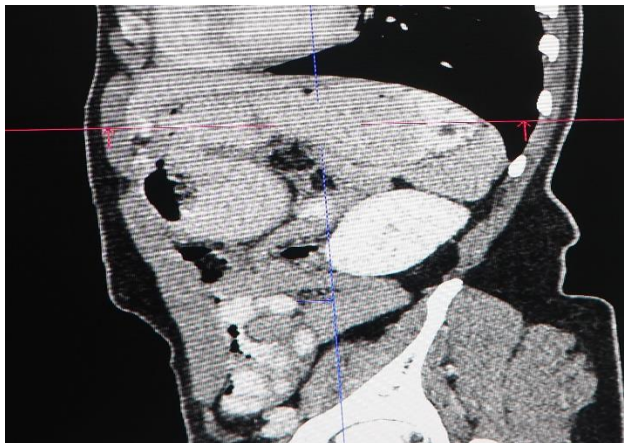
Abdomen CT scan showing the “cup and spill stomach” biloculated gastric cavity dilatation with the pyloro-duodenal mural asymmetric wall thickening causing luminal narrowing.
